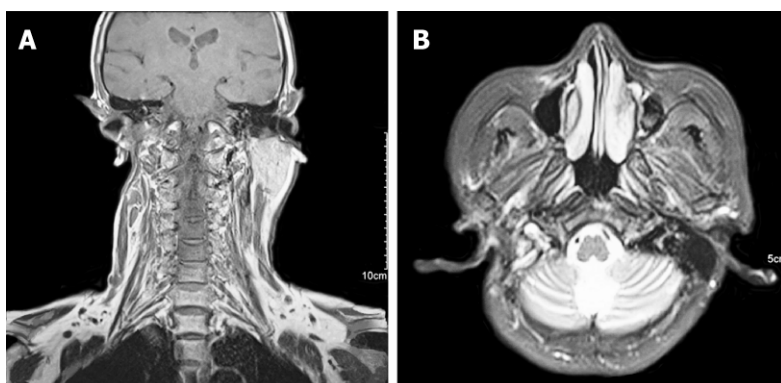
Post-operative magnetic resonance imaging of the patient 3 mo after operation. No obvious residual tissue and no recurrence of the tumour. A: Coronal; B: Axial. (July 2017)
